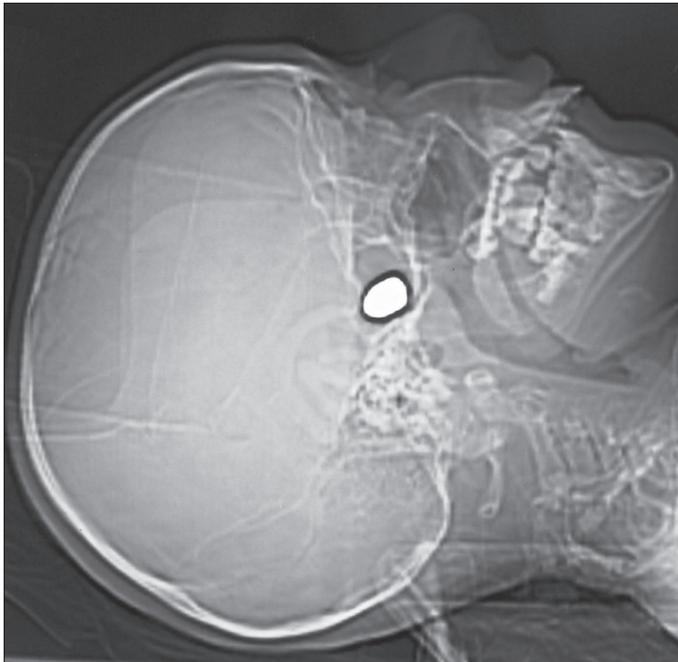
Computed Tomography scans revealed left temporal bullet
